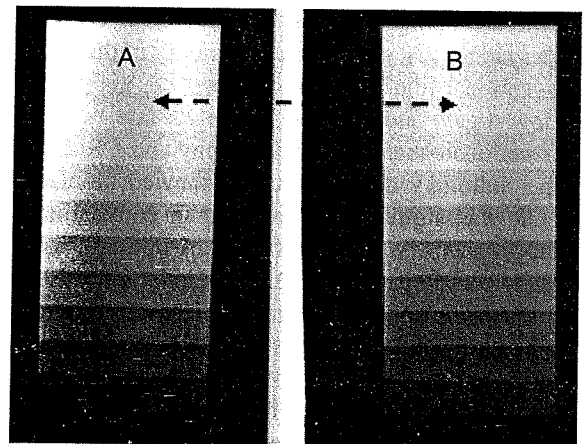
Radiograph showing the result of mAs reciprocity test. Dashed line is the corresponding steps
